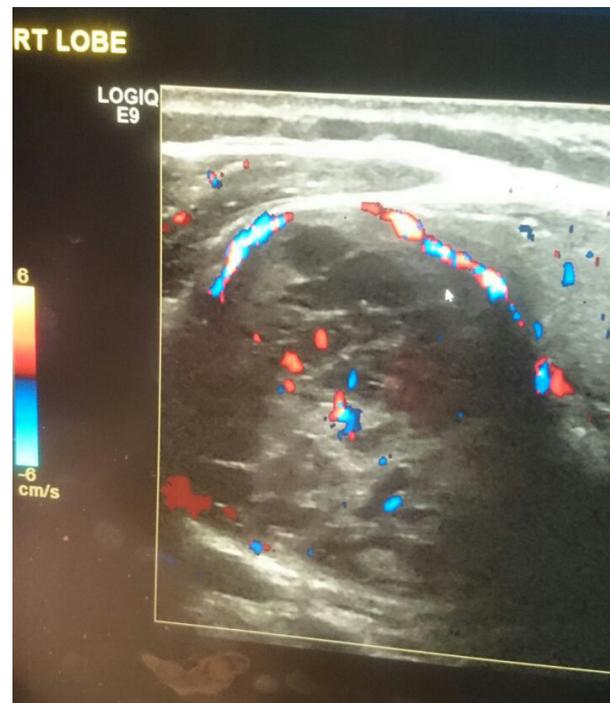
Neck ultrasound showing right thyroid lobe enlargement measuring 3.3x3.5x5 cm and a large cystic solid nodule in the right lobe.
